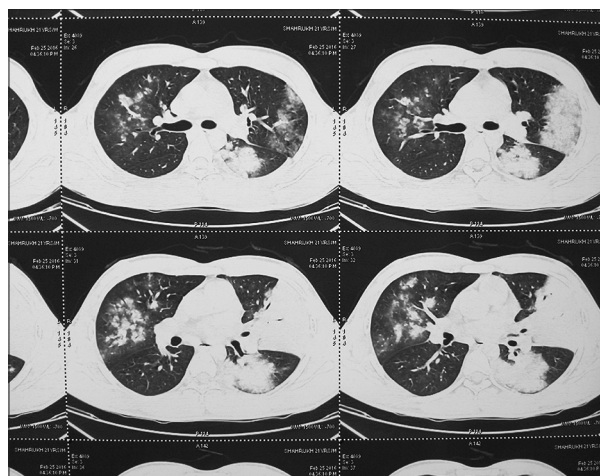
Computed tomography chest, lung window, axial cuts showing bilateral consolidation with surrounding ground glass opacities
